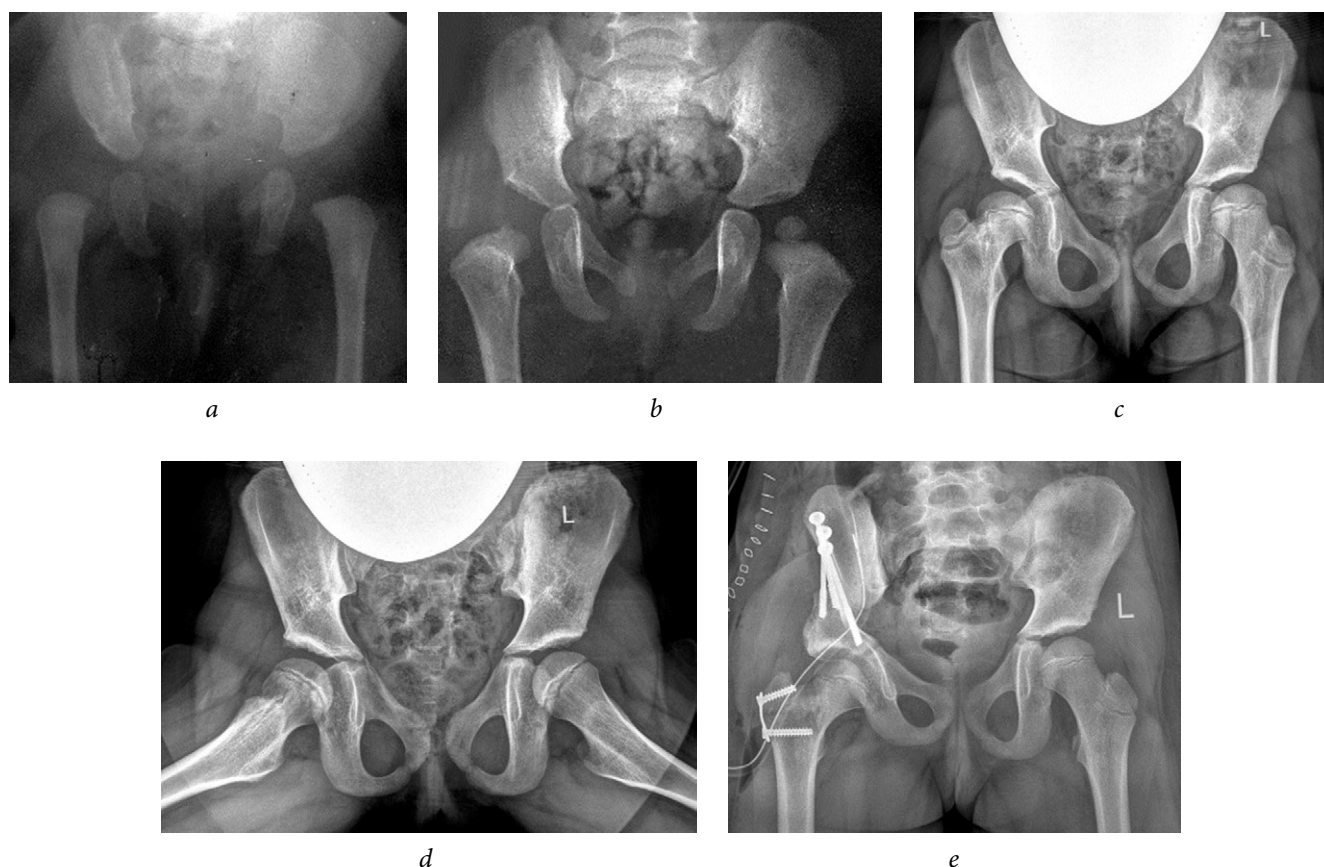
Radiographs of patient U (7 years old) diagnosed with congenital dislocation of the right hip, condition after conservative treatment, and residual developmental hip dysplasia. Complications of aseptic necrosis of the femoral head include femoral neck shortening, formation of Kalamchi type II deformity, and high position of the greater trochanter: a, at 4 months old; b, at 1 year old; c, d, at 7 years old, before surgery; e, immediately after iliac pelvic osteotomy and trochanteric epiphysiodesis on the right
